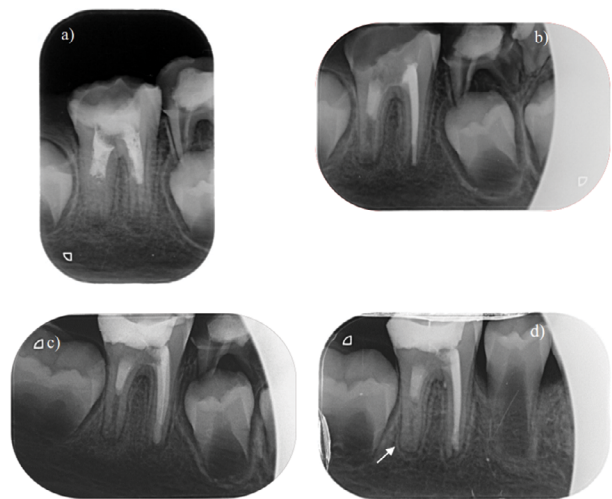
Calcification of the root canal. a) Initial X-ray after calcium hydroxide application. The patient was referred after emergency treatment and application of calcium hydroxide for one week; b) Follow-up after REP of the distal root and confirmation of the working length for the mesial canals; c) Follow-up after 12 months; d) Follow-up after 24 months - almost complete obliteration of the distal root and increase in the length of the mesial root has occurred.
